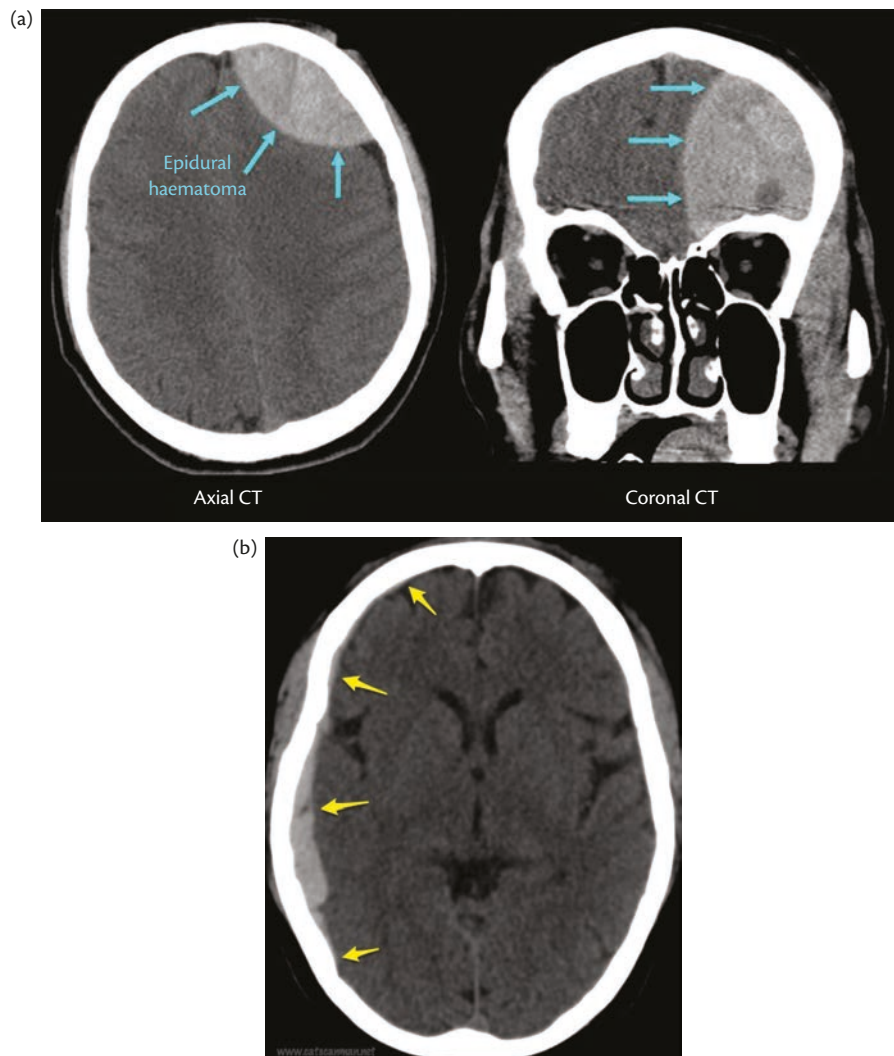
(a) Extradural haematoma detected by CT scanning. (b) Subdural haematoma detected by CT scanning.
